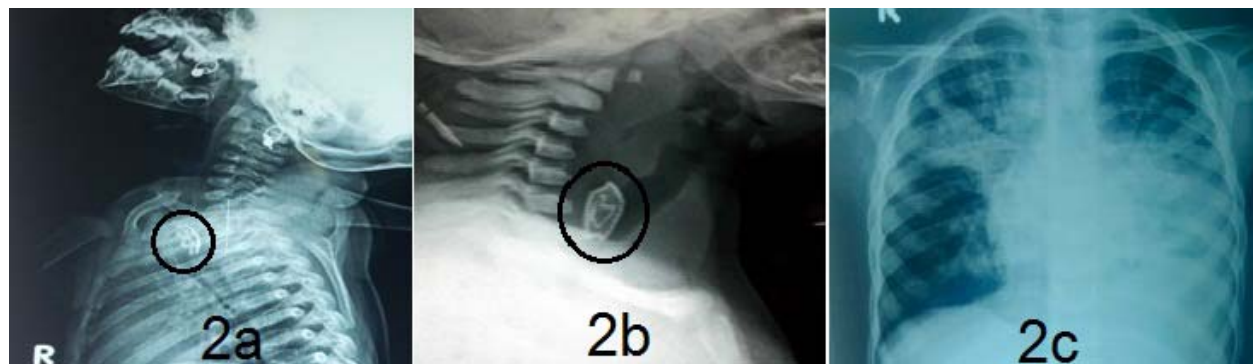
(a) Lateral view chest radiograph (case 2) shows a button with multiple holes in trachea, (b) sticker (case 3) in airway in front of C7 vertebrae on X-ray neck lateral view, (c) multiple bilaterally heterogeneous opacities (case 4) on chest X-ray (PA view).
